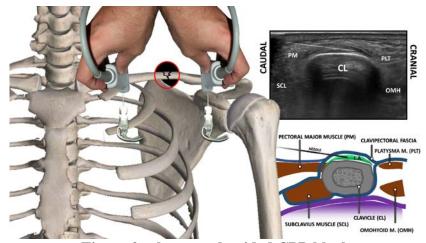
ultrasound guided CPB block
